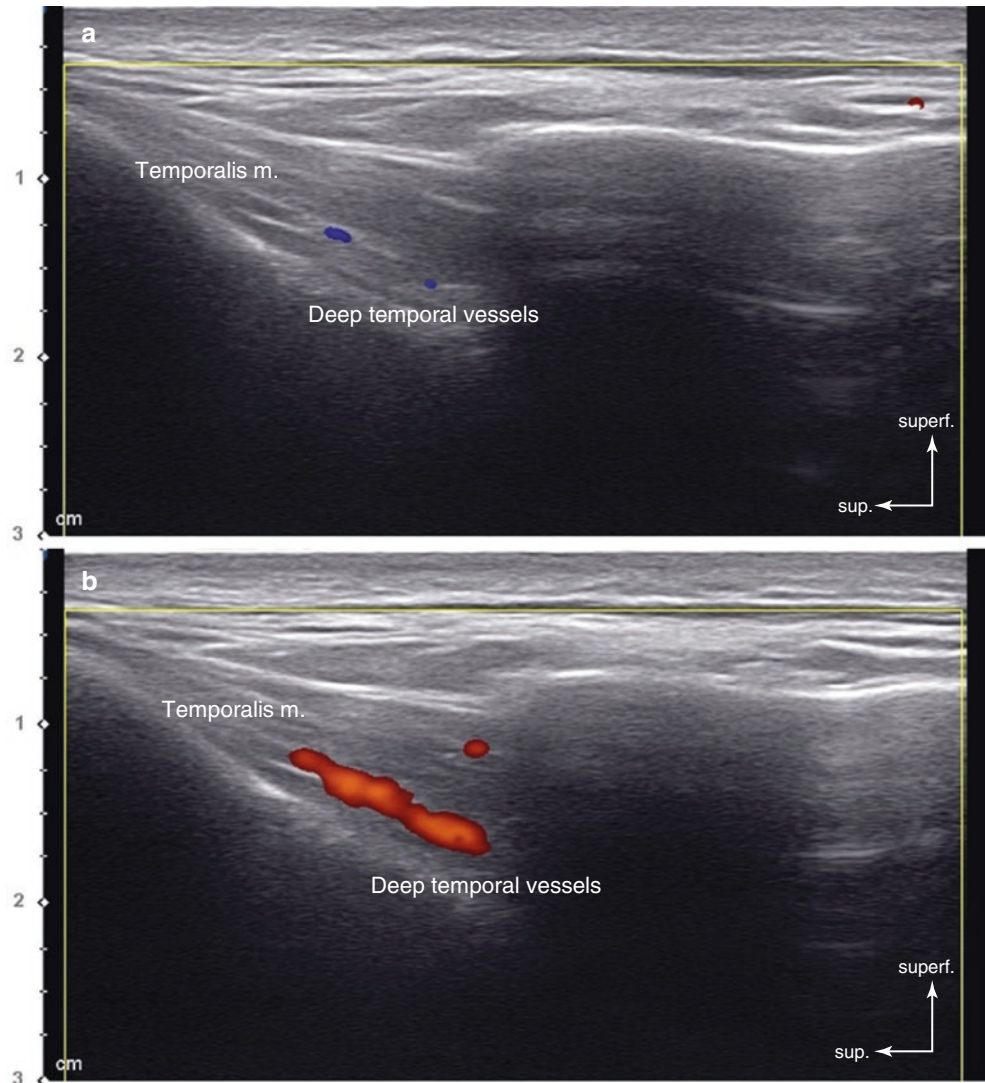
Power Doppler image of deep temporal artery at the temple. (a) Color Doppler image and (b) power Doppler image. (Published with kind permission of © Hee-Jin Kim 2020. All Rights Reserved)
